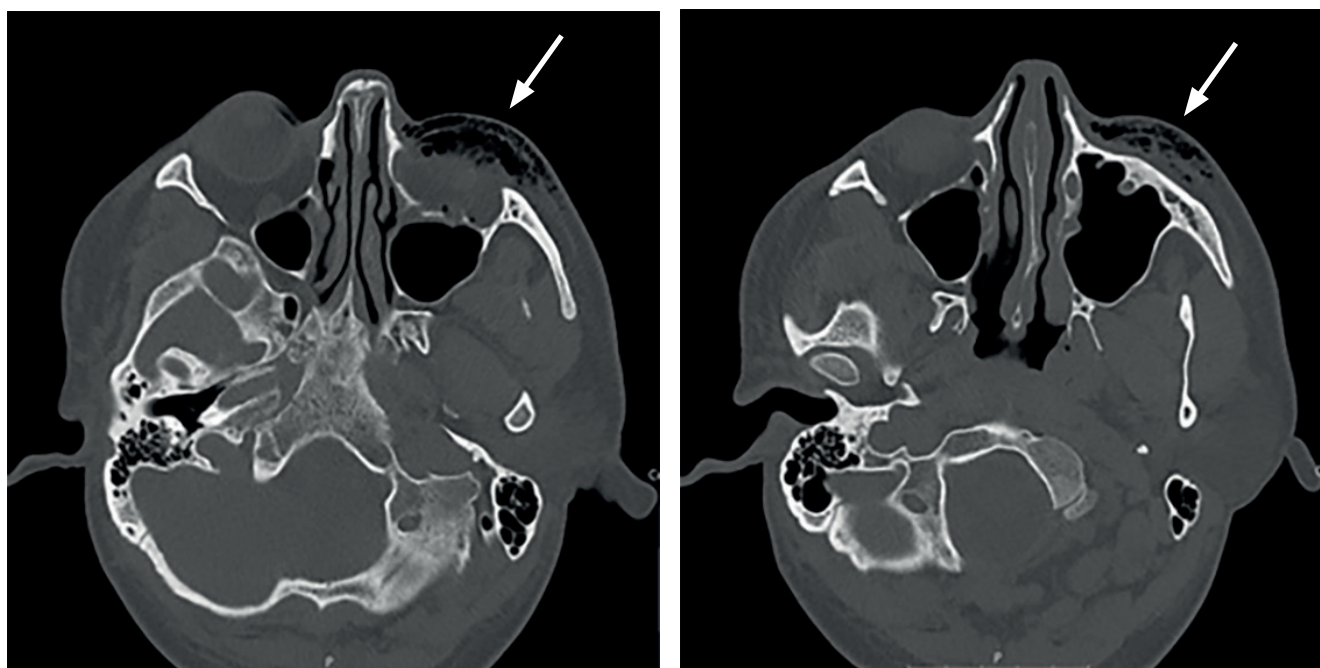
CT orbit demonstrating surgical emphysema in the left orbit. There is comminuted fracture of the floor of the posterior left orbit and superior maxillary wall.
